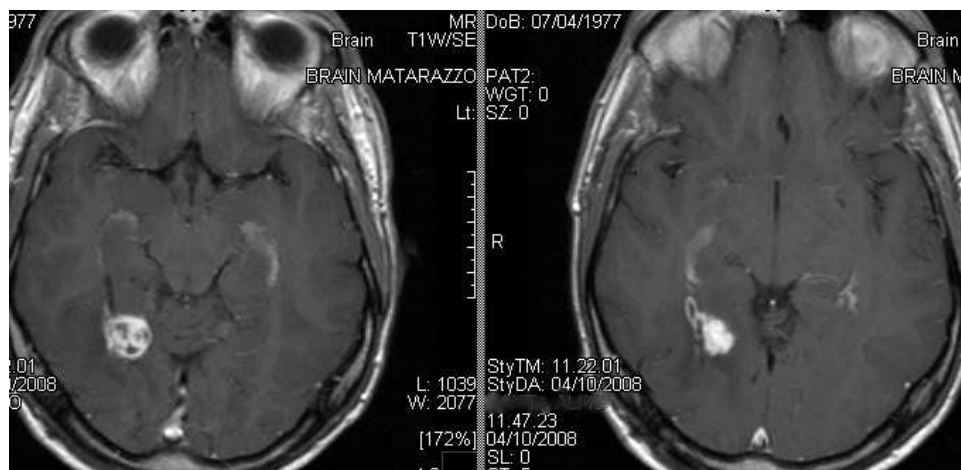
Same case than in figures 1. MRI follow up at 32 months from GKRS showing a significant tumor reduction.
